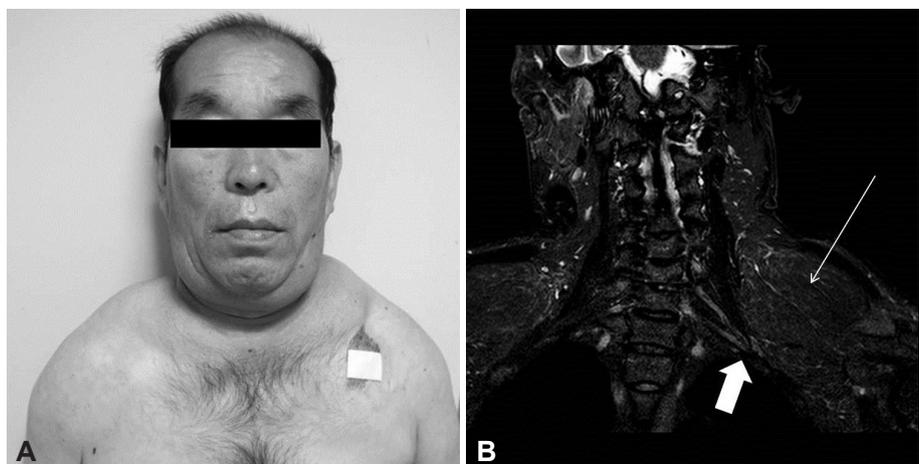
A: Excessive fatty tissues around the neck and shoulder. B: Coronal fat-suppressed T2-weighted MRI reveals the brachial plexus (thick arrow) compressed by lipoma (thin arrow).
